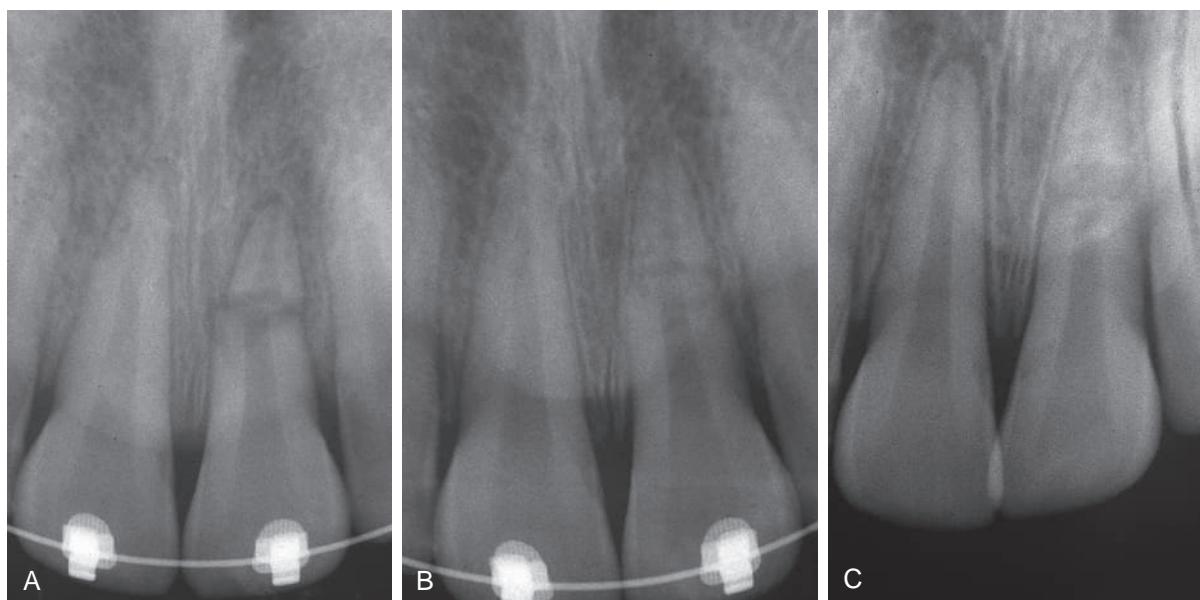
(A) Root fracture is evident in the apical one-third of the maxillary left central incisor. A splint was placed the day of the fracture. The patient reported that both teeth received trauma (via a baseball to the area), although only the root of the maxillary left central incisor was fractured. (B) One month after initial splint placement. Both central incisors responded favorably to pulp testing, and the splint was removed. Periodic evaluation and pulp testing were maintained. (C) More than 2 years had elapsed when this radiograph revealed a normal periapical appearance to the maxillary left central incisor with the fractured root. Pulp testing for the incisor was normal. The patient complained of pain associated with the maxillary right central incisor (see developing periapical lesion) and was referred for endodontic evaluation.
